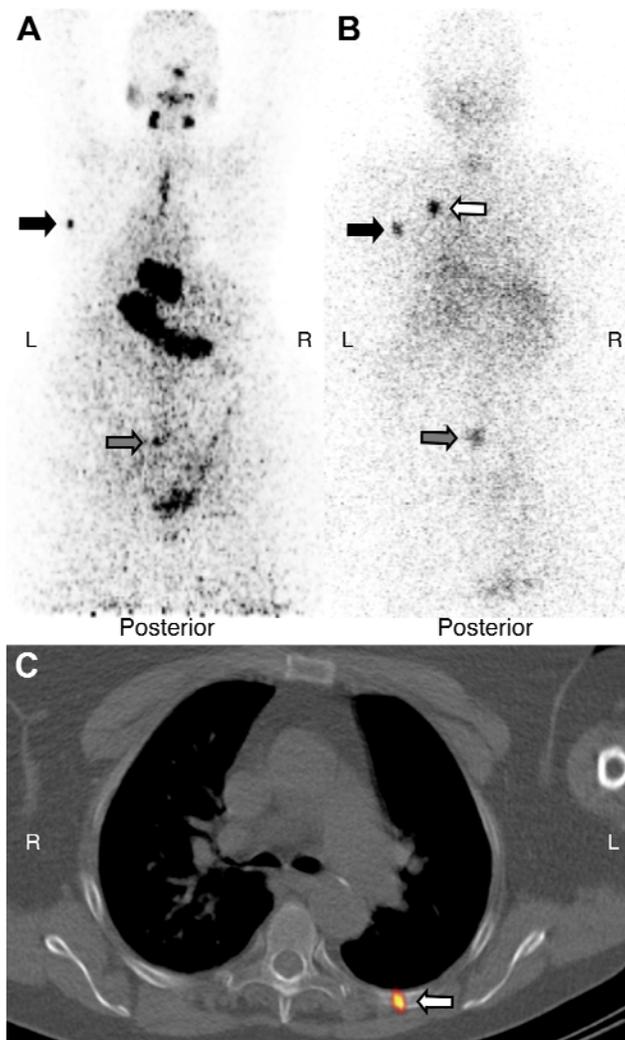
Patient with one iodine-positive metastasis (no. 5), which was not detected by ^{124}I PET (A, MIP, posterior view) but by ^{131}I WBS (B, planar posterior image) and SPECT/CT (C, axial). The black arrows mark an iodine-positive metastasis in the left scapula and the grey arrows a metastasis in the lower lumbar spine. The white arrow in images (B, C) points at a metastasis in a rib, only detected by ^{131}I images.
